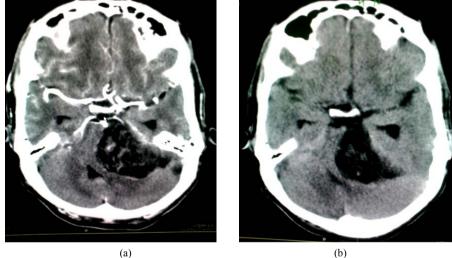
Axial CT brain images (b) without contrast and (a) with contrast showed a mixed lesion in the left cerebellar hemisphere crossing the midline with contrast enhancement. Astrocytoma.
